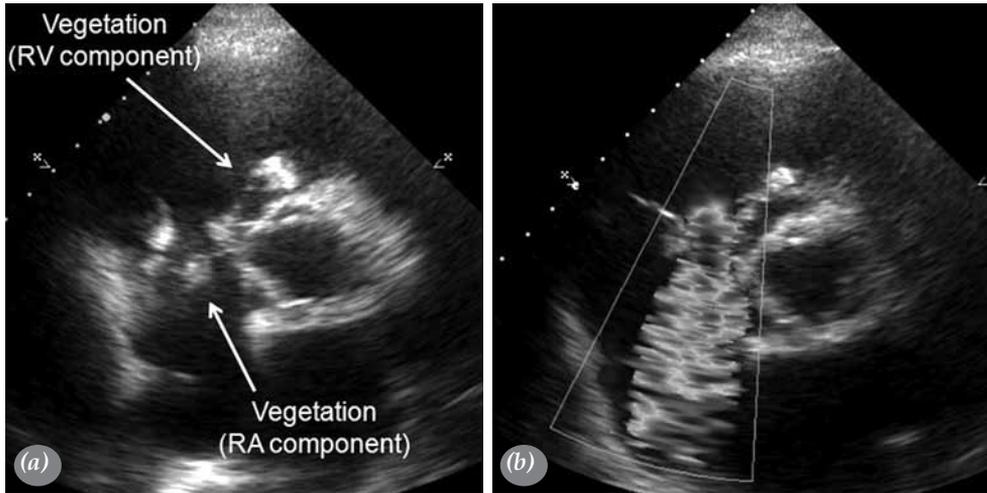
(a) Transthoracic echocardiography showing a long, mobile, hyperechogenic mass consistent with vegetation extending from the tricuspid leaflets to the right ventricle (RV) and continuing into the right atrium (RA) (left side). (b) The mass was causing severe tricuspid regurgitation (right side). The right ventricular (RV) component of the vegetation was larger than the RA component.
